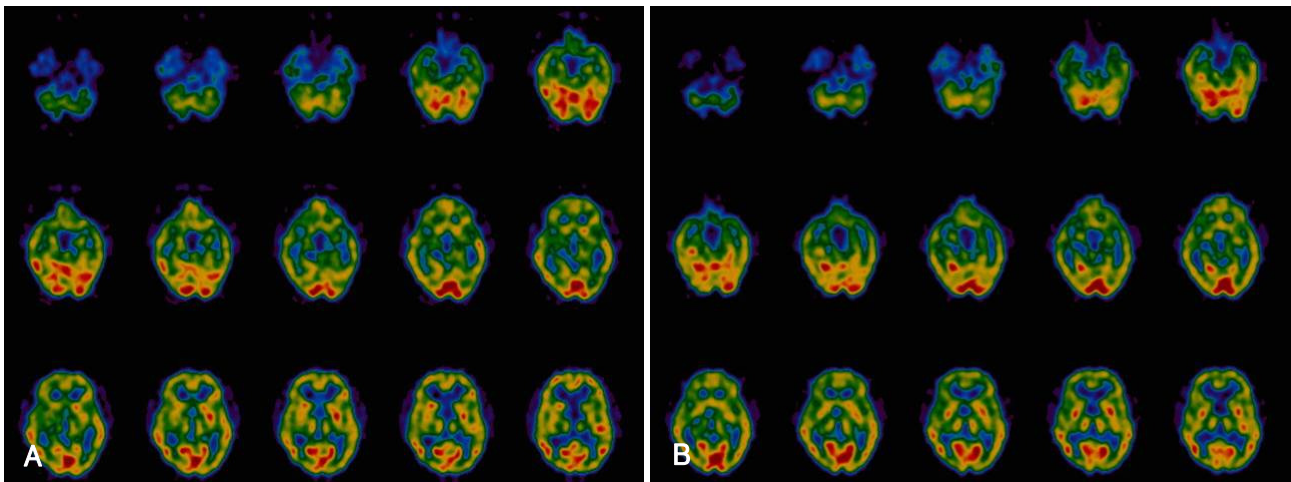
Single-photon emission CT scanning with a ^{99m}Tc -ethyl cysteinate dimer obtained after endovascular recanalization. A: cerebral blood flow at rest increased in the right frontotemporal region compared to that before treatment. B: vascular reactivity for the Diamox challenge also recovered.
